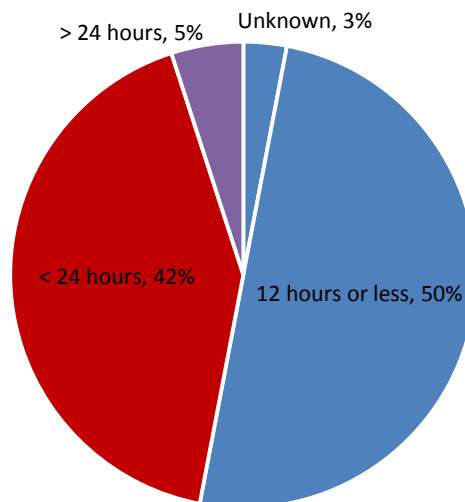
Wait time for non-emergent CT scan: Finger Lakes Region, 2014
